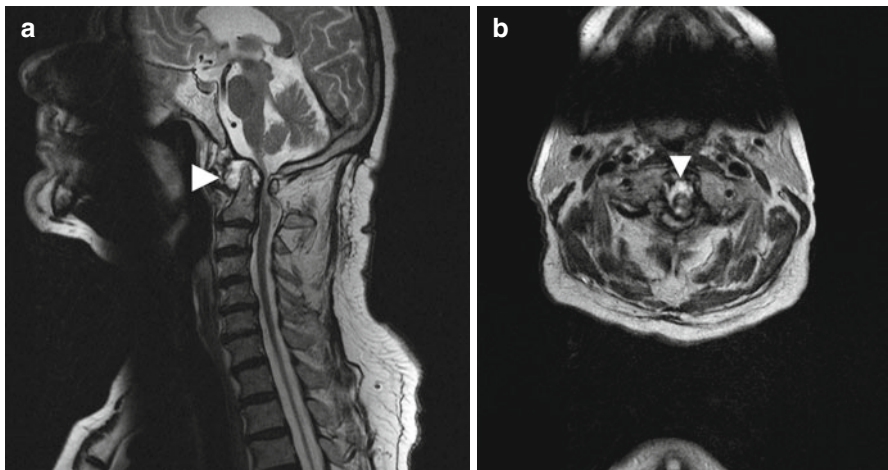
Extensive pannus formation (*arrowhead*) around the tip of the dens in rheumatoid arthritis on sagittal T2w TSE image (a) and axial T2w TSE image (b). Large mass effect with atlantodental joint gap. There is high-grade myelopathy due to compression of the spinal cord. The subject only has mild ataxia, which is not consistent with the severity of these MRI abnormalities. The discrepancy suggests that the changes developed slowly
